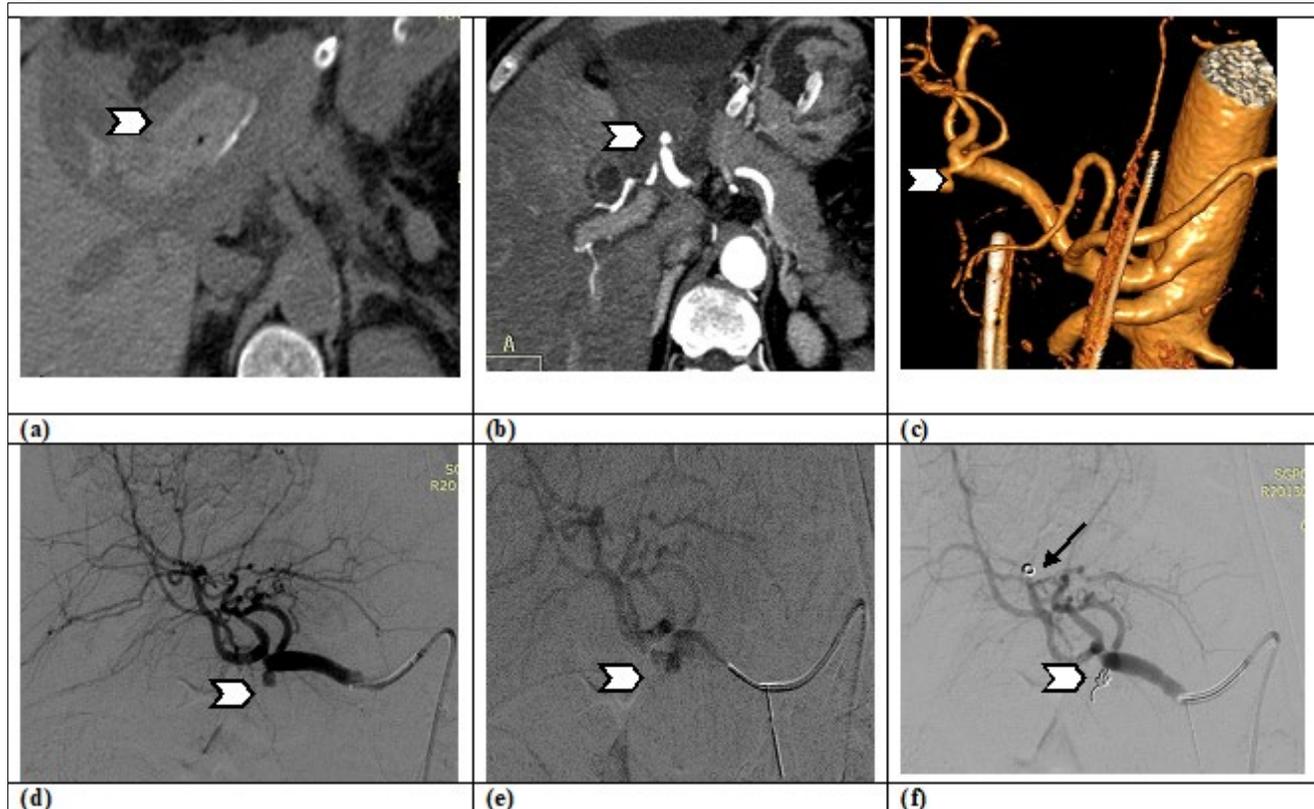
Showing a 55 year old female underwent Whipple's pancreaticoduodenectomy procedure for periampullary carcinoma. (a) NCCT image shows bleed (arrowhead) into the jejunum. (b) CTA MIP, MPR image shows GDA stump pseudoaneurysm (arrowhead) (c) VR image better shows the GDA stump pseudoaneurysm (arrowhead). (d) DSA image with selective cannulation of the common hepatic artery showing pseudo-aneurysm (arrowhead). (e) Rupture of the pseudoaneurysm (arrowhead) during the embolisation. (f) Post coil embolisation check angio shows no filling of the pseudo-aneurysm (arrowhead). There was coil in the right hepatic artery (black arrow).
